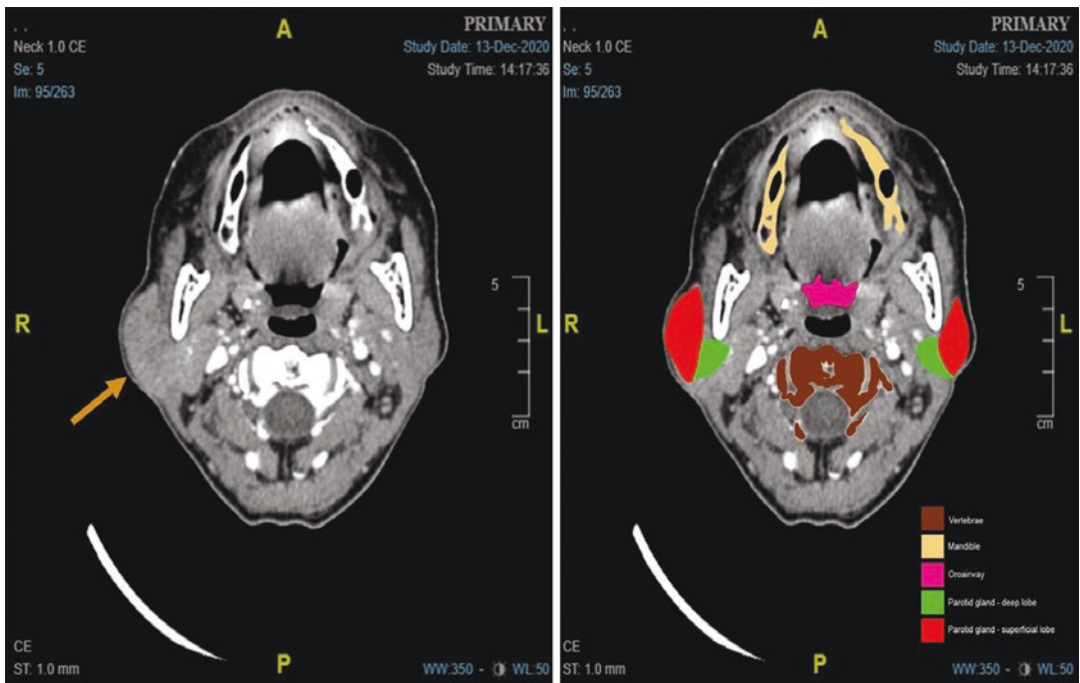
CT scan showed a homogenous mass arising from the right parotid glands with minimal deep lobe involvement (green) on the right parotid gland (arrow). The image mapping in colours for other structures' identification
